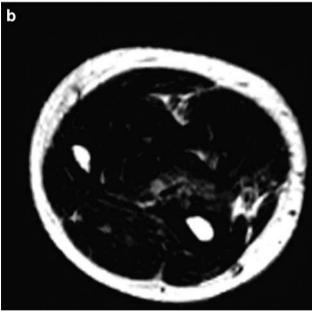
A 12-year-old girl with a rhabdomyosarcoma of the right forearm (a) showed complete disappearance of the tumour on MR images (T2 weight image) after five courses of caffeine-potentiated chemotherapy (b).
